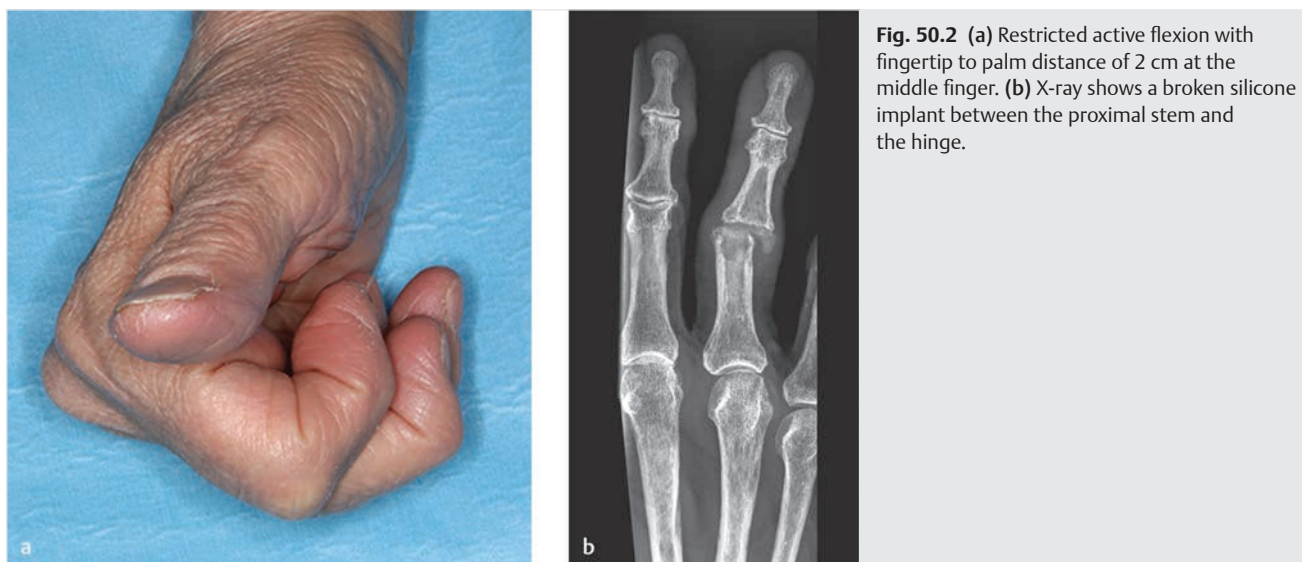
(a) Restricted active flexion with fingertip to palm distance of 2 cm at the middle finger. (b) X-ray shows a broken silicone implant between the proximal stem and the hinge.
